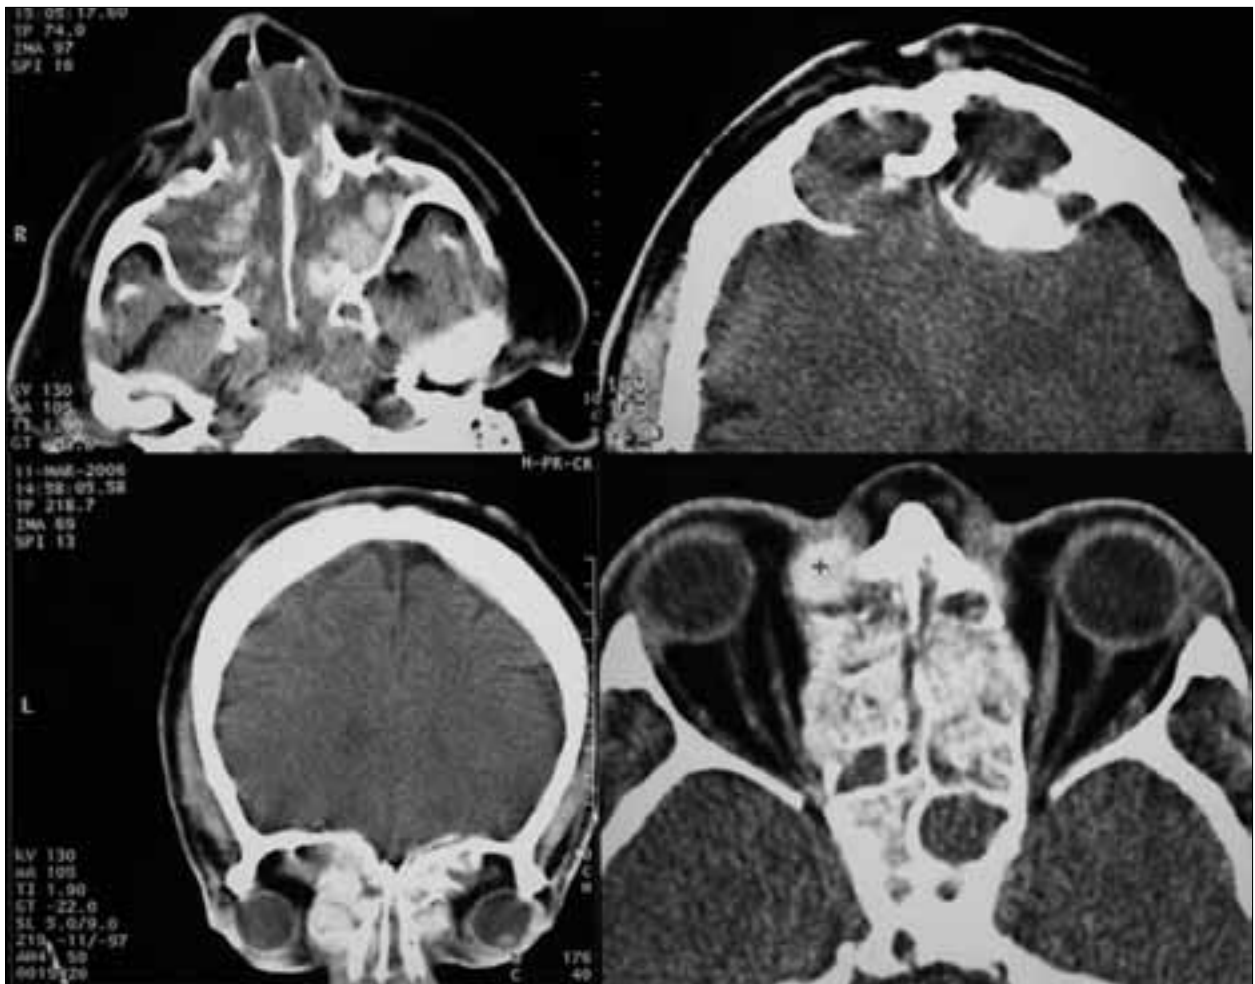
Computed tomography (CT) of the brain and paranasal sinuses showed a soft-tissue mass completely filling both nasal passages, maxillary and frontal sinuses, ethmoidal cells, sphenoid sinus, accompanied by destruction of bony walls
